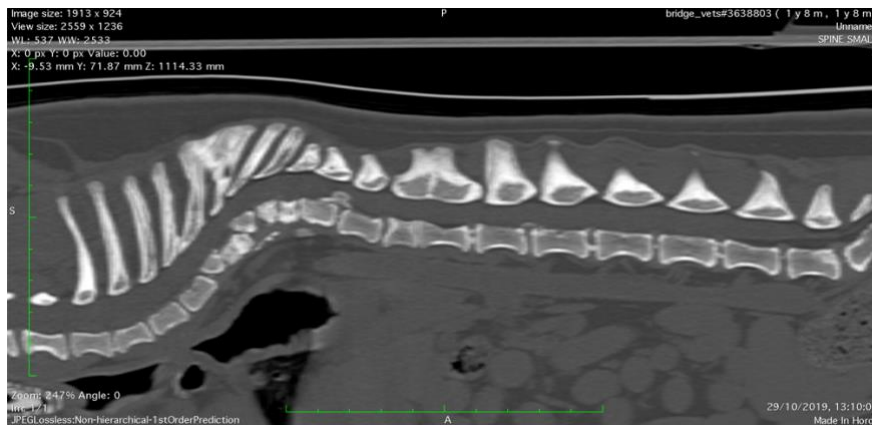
CT 3D MPR Sag thoraco-lumbar
